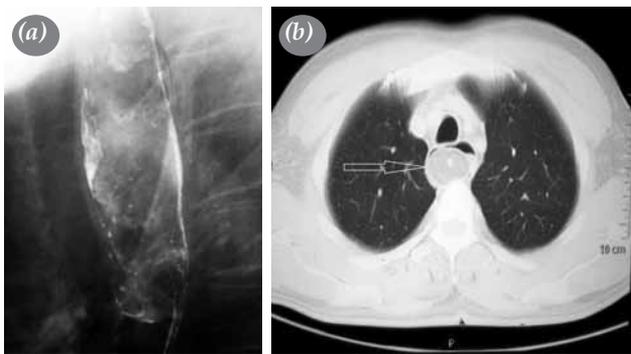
(a) A barium swallow showed an 8x15 cm smooth tumor in the upper part of the esophagus. (b) Chest computed tomography revealed an 8x15 cm submucosal tumor (arrow) with narrowing in the upper third of the thoracic esophagus.
